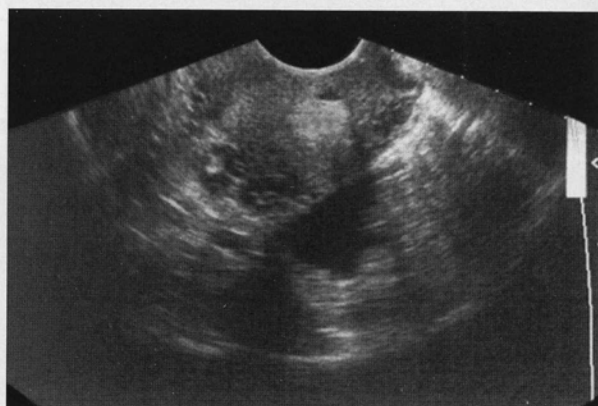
Free fluid along the posterior wall of the uterus. Reprinted from Kendall JL, Deutchman M. *Ultrasound in Emergency Medicine and Trauma*. Nashville: Healthstream Inc. 2001, with permission.
